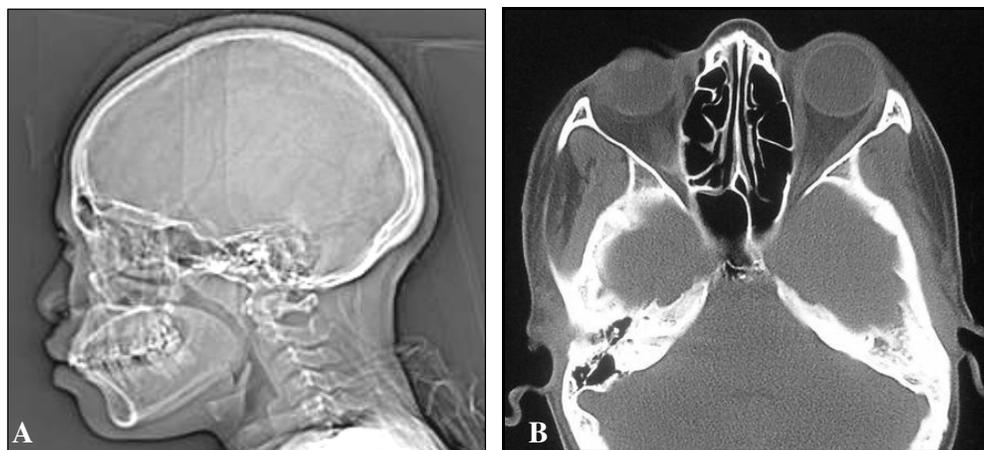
A: Topogram view of a CT scan. B: A typical horizontal slice view from a CT scan
